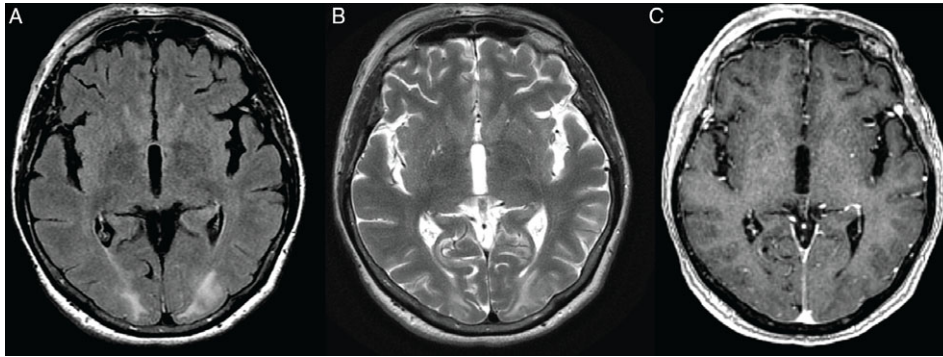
MRI brain on initial presentation. (A) Axial FLAIR sequence depicting hyperintensity in the bilateral occipital white matter consistent with PRES. (B) T2-weighted image showing similar bilateral occipital white matter hyperintensity. (C) Post-gadolinium image shows no abnormal enhancement.
